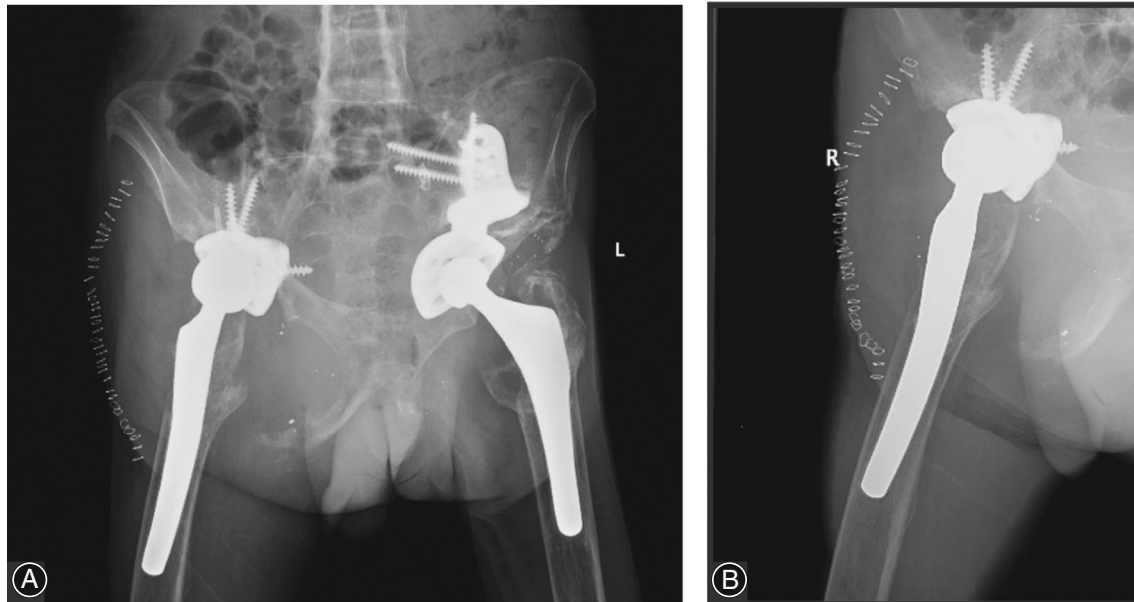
Anteroposterior (A) and lateral (B) radiograph after right revision THA.
